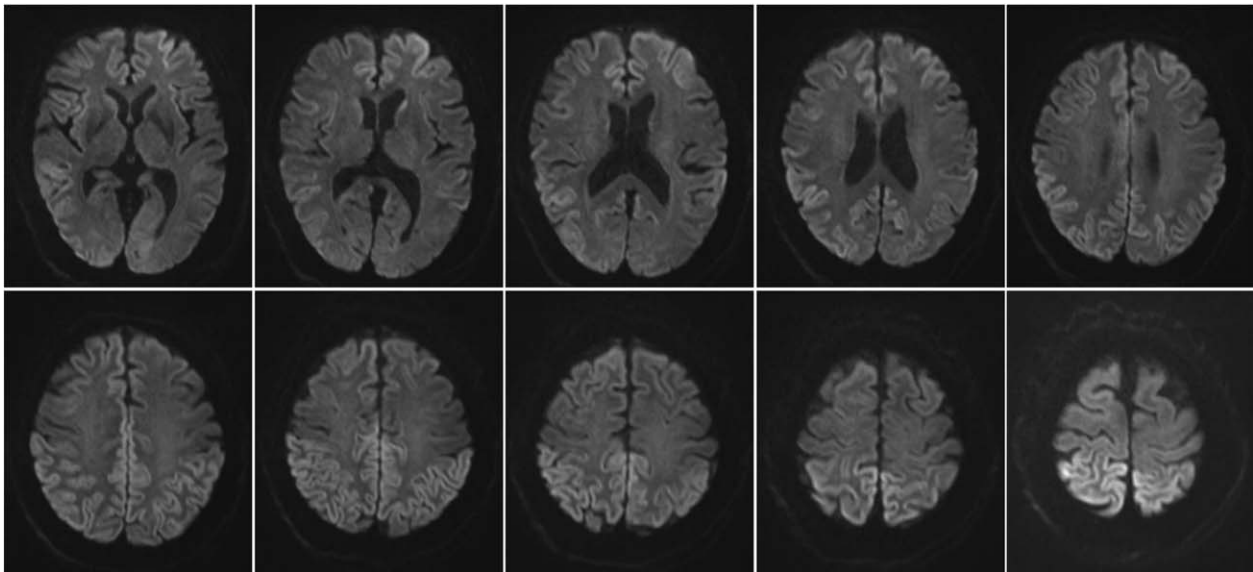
The DWI of the patient showed a slight increase in signal intensity in the bilateral parietal occipital and frontal lobes. DWI=diffusion weighted imaging.
